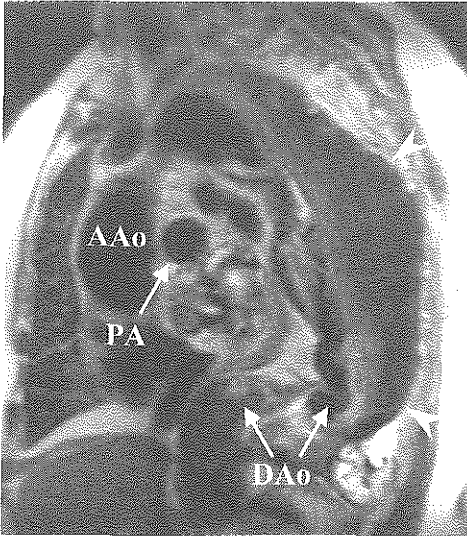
Example of spin-echo MRI in patient with an aneurysm of the descending aorta (DAo). The normal flowing blood in the ascending aorta (AAo) and pulmonary artery (PA) is black, while the mural thrombus and slow flowing blood in the descending aorta produce some signal and therefore is gray in the image (arrow heads).
